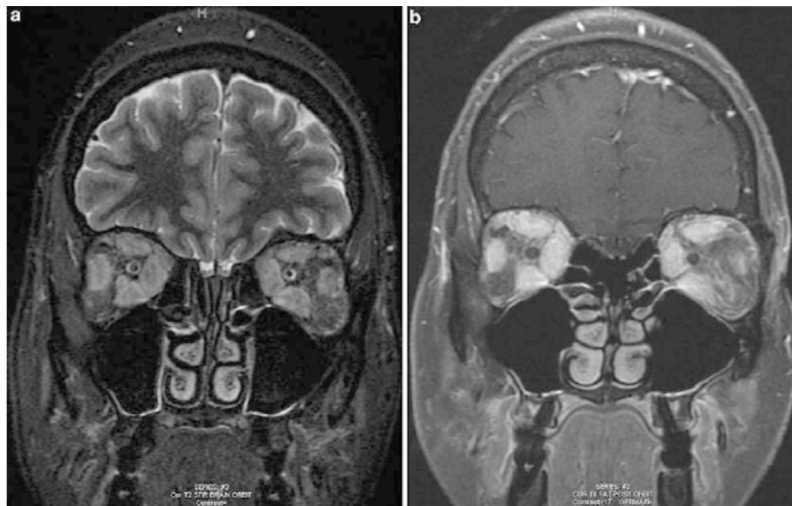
Magnetic resonance imaging of orbit in a patient with strabismus. (a) Coronal T2 STIR, (b) Coronal T1 fat suppression postcontrast MRI, marked enlargement of the extraocular muscles bilaterally, with greatest involvement of the superior, medial, and inferior recti. There is heterogeneity within the orbital fat
